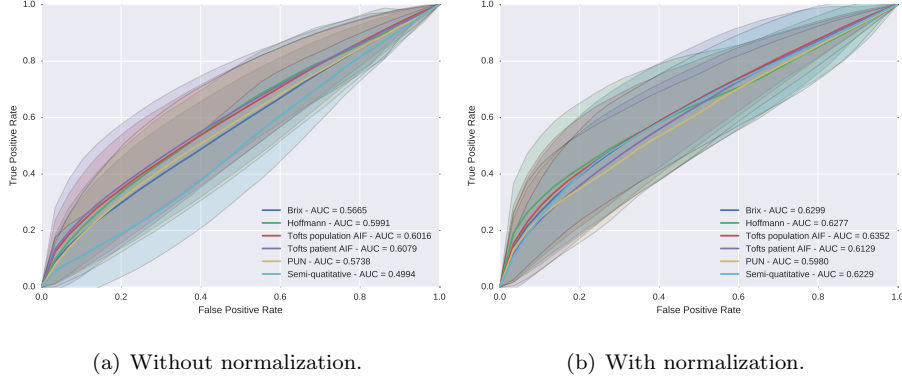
ROC analysis using a RF classifier with and without normalization DCE-MRI data for different pharmacokinetic models.
